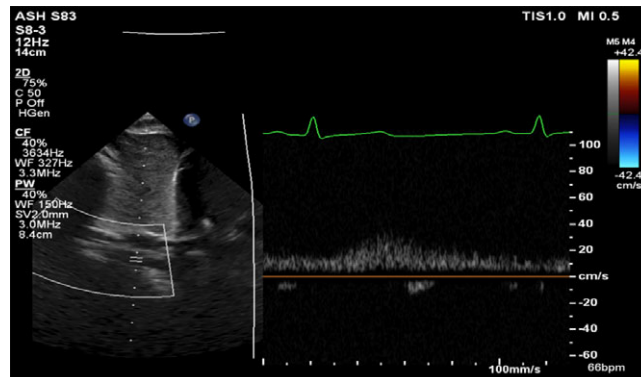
Subcostal duplex Doppler showing lack of pulsatility in the abdominal descending aorta. Low-velocity continuous flow is similar to a venous flow profile.
